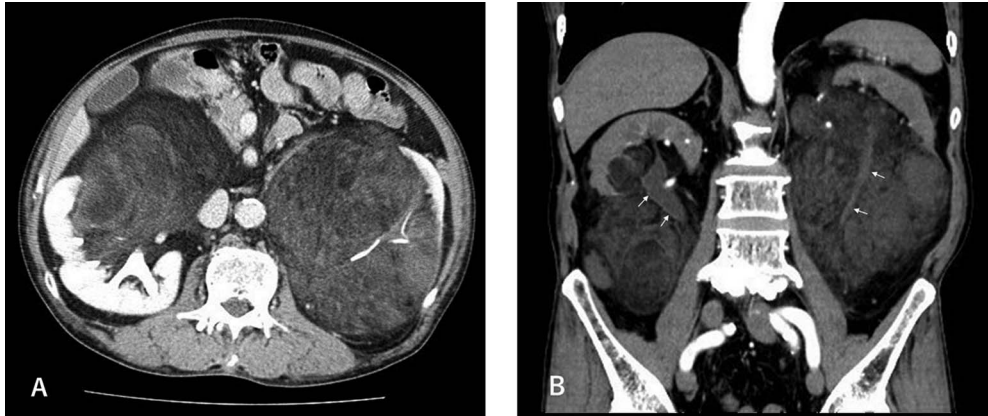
(A) Axial enhanced CT image showing bilateral giant masses arising at the renal sinuses; (B) sagittal enhanced CT image showing masses displacing the kidneys superolaterally and lack of dilatation of the pelvis or ureter (arrow).
